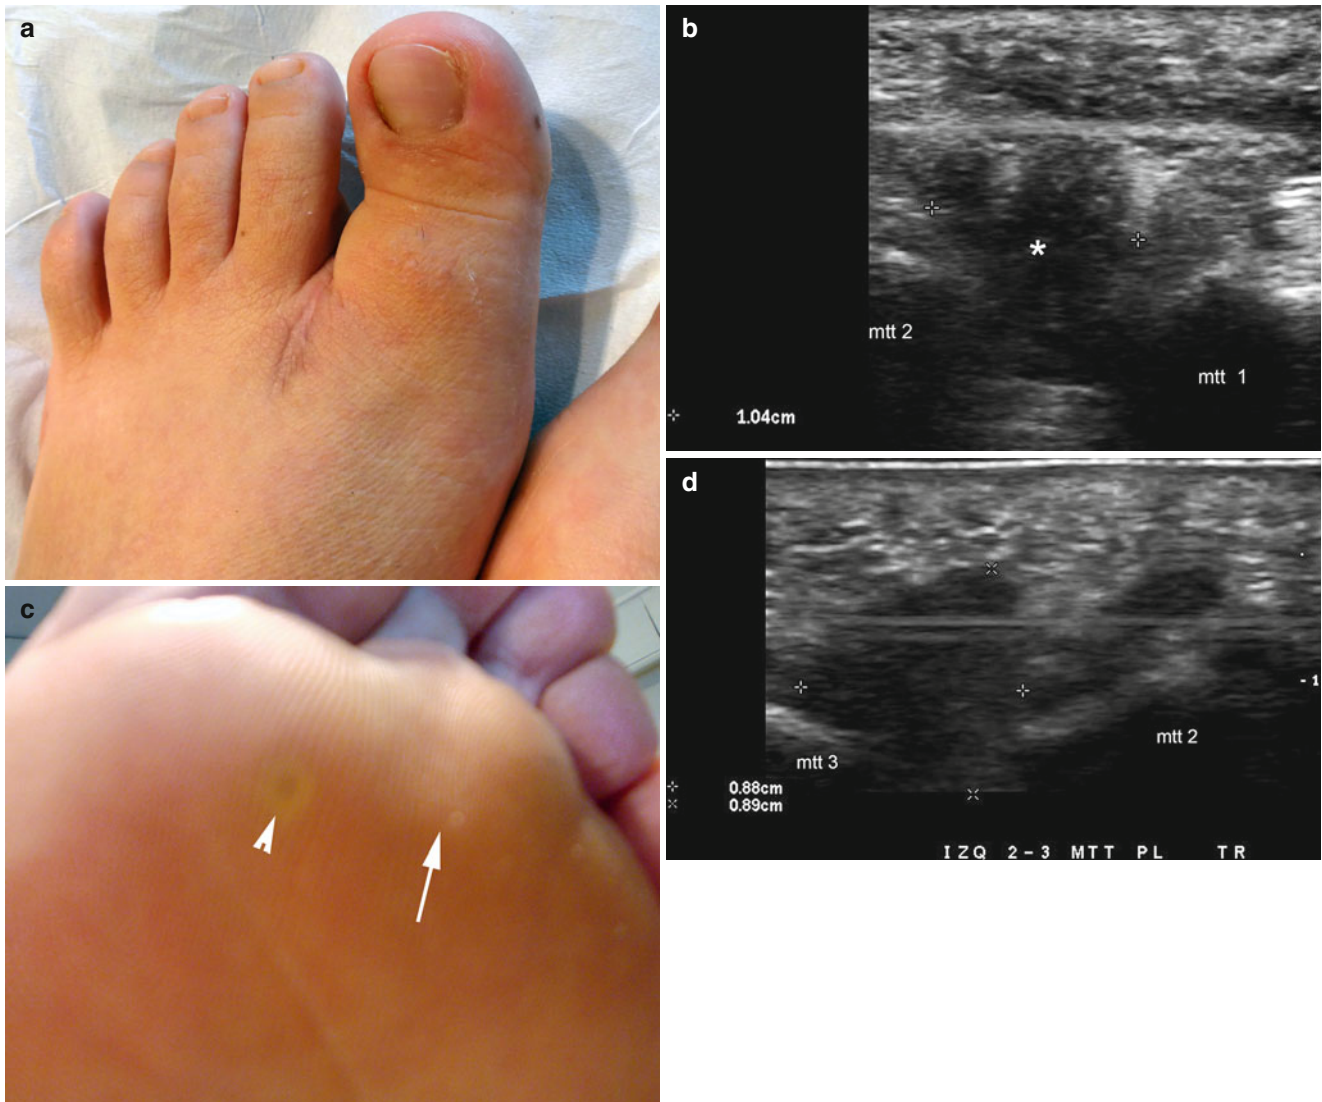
(a–d) Morton’s neuroma. (a) Clinical image of a patient that presented with a history of corrective surgery and excruciating pain in the first intermetatarsal space of the right foot. (b) Grey scale ultrasound image (transverse view, same patient of figure a) demonstrates a 1.04 cm (wide), ill-defined lobulated hypoechoic solid structure (*) in the space between the first and second metatarsal bones. (c) Clinical
